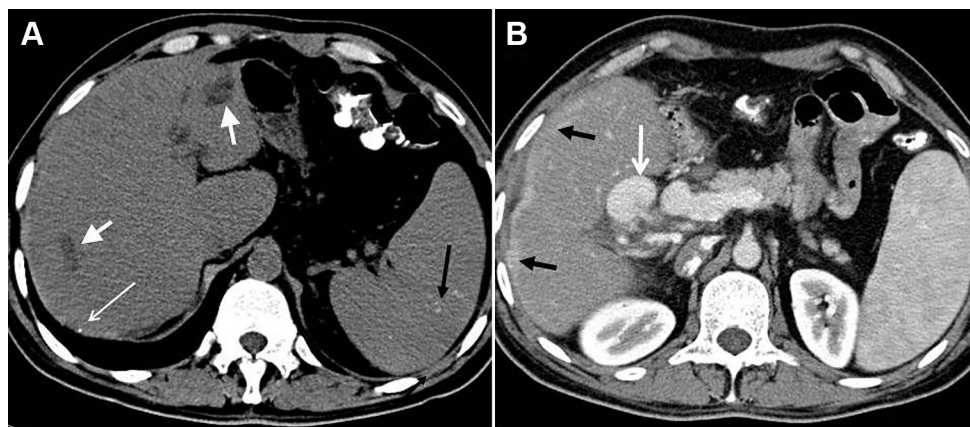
Noncontrast CT image demonstrates (A) caudate lobe hypertrophy (long arrows), intrahepatic bile duct dilatation (short white arrows), millimetric calcification in the liver capsule (open arrow), and siderotic nodules in the spleen. Contrast-enhanced, portal venous phase CT image demonstrates (B) contrast enhancement of the liver capsule (black arrows) and portal vein dilatation (white arrows).
